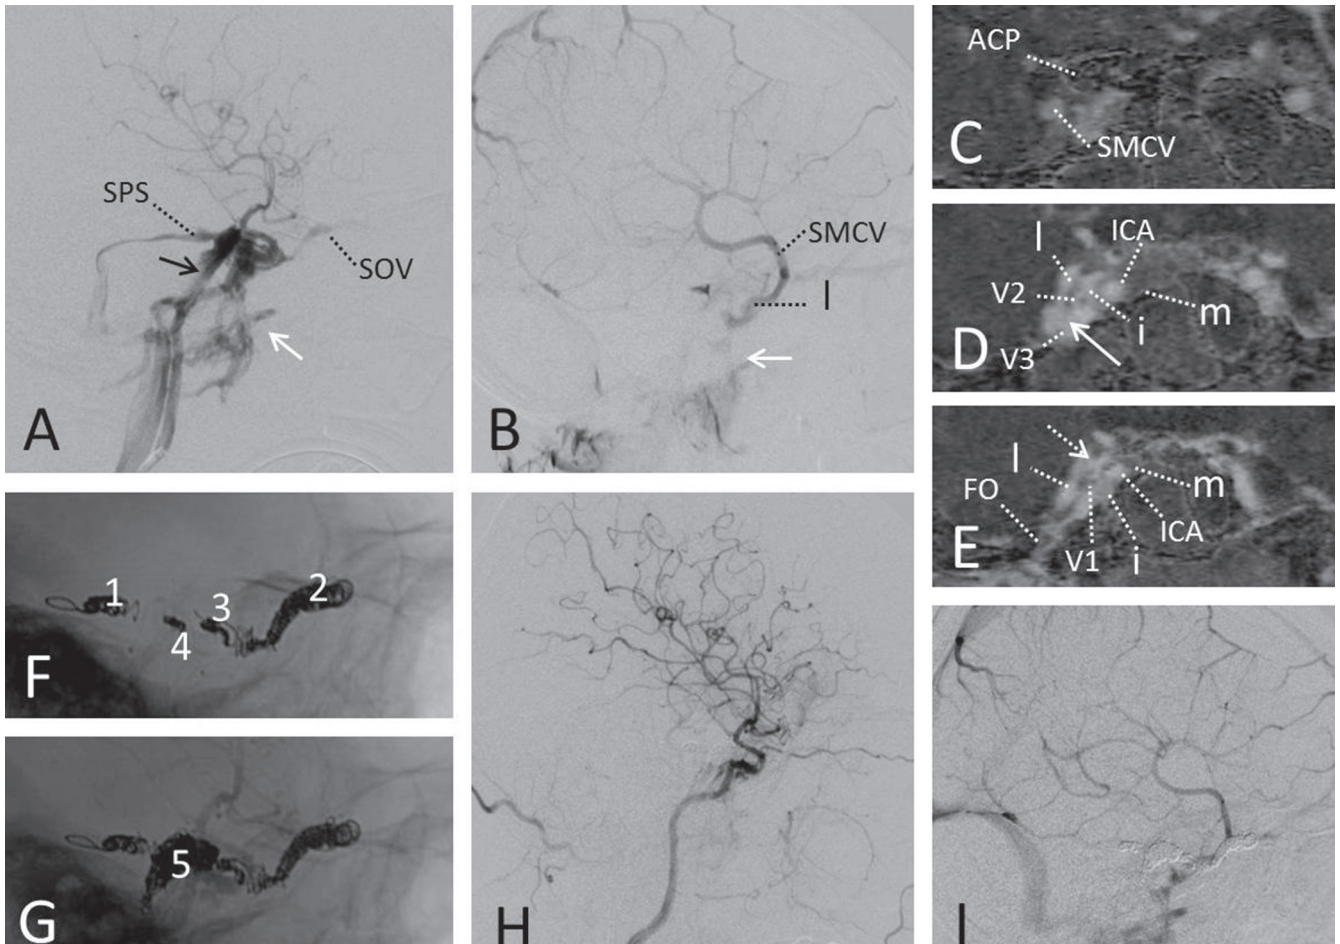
Traumatic carotid-cavernous fistula (CCF). A 54-year-old male presented with exophthalmos and visual loss on the right side after serious head trauma. A: Right carotid angiogram (lateral view) showed a direct CCF at the posterior genu of the right internal carotid artery (ICA) draining antegradely into the inferior petrosal sinus (*arrow*) and the pterygoid plexus (*white arrow*), retrogradely into the superior ophthalmic vein (SOV) and the superior petrosal sinus (SPS). B: Venous phase of the angiogram showing that the antegrade venous drainage of the superficial middle cerebral vein (SMCV) into the pterygoid plexus (*white arrow*) through the lateral venous axis (l) was still preserved. C–E: Preoperative coronal bone-subtraction computed tomography angiograms, anterior (C) to posterior (E). C: The cross-section at the level of anterior clinoid process (ACP) showed the SMCV, which posteriorly connected to the lateral venous axis. D, E: There were two venous pathways connecting the lateral venous axis (l) to the intermediate venous axis (i). The one (*white arrow*) was through the aperture between the 2nd division (V2) and the 3rd division (V3) of the trigeminal nerve. The other (*white dotted arrow*) was beyond the 1st division (V1) of the trigeminal nerve. The medial venous axis (m) was thrombosed on the right side due to the trauma. F, G: Fluorographic images during transvenous embolization through the inferior petrosal sinus. Connections to the SPS (1), the SOV with the part of the intermediate axis anterior to the venous connection between V2 and V3 (2), the extension of the intermediate axis posterior to the venous connection with the emissary vein of the foramen ovale (3), and the posterior part of the lateral axis with the venous connection to the intermediate venous axis beyond V1 (4) were embolized. With these embolizations, the antegrade drainage pathway of the SMCV was completely isolated from the shunt flow. Finally, the fistulous-dilated compartment beyond the posterior genu of the ICA (5) was embolized. H: After the embolization, almost all the shunt flow had stopped without any cortical venous reflux. I: The antegrade flow of the SMCV was preserved through the anterior part of the lateral venous axis, the venous channel between V2 and V3, the remaining middle part of the intermediate venous axis, and the emissary vein of the foramen ovale into the pterygoid plexus. ICA: internal carotid artery. FO: foramen ovale.
